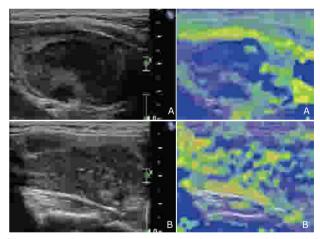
Real time elastosonography shows most of the nodule in the left lobe is blue and a small part of it is green (A). Elasto- sonography shows the hypoechoic area in the right lobe is composed of blue, green, and yellow (B).
